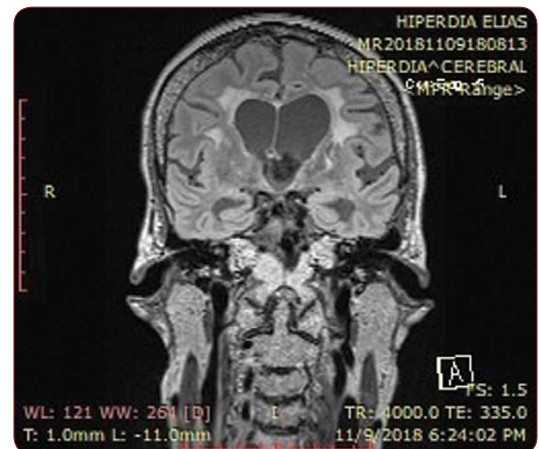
Coronal FLAIR MR shows enlarged lateral and third ventricles with interstitial edema along the lateral ventricles' margins
